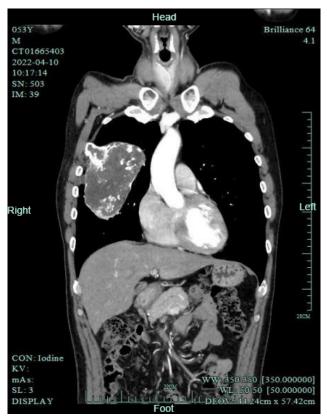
The Contrast-enhanced chest CT shows the tumor in the coronal plane.
